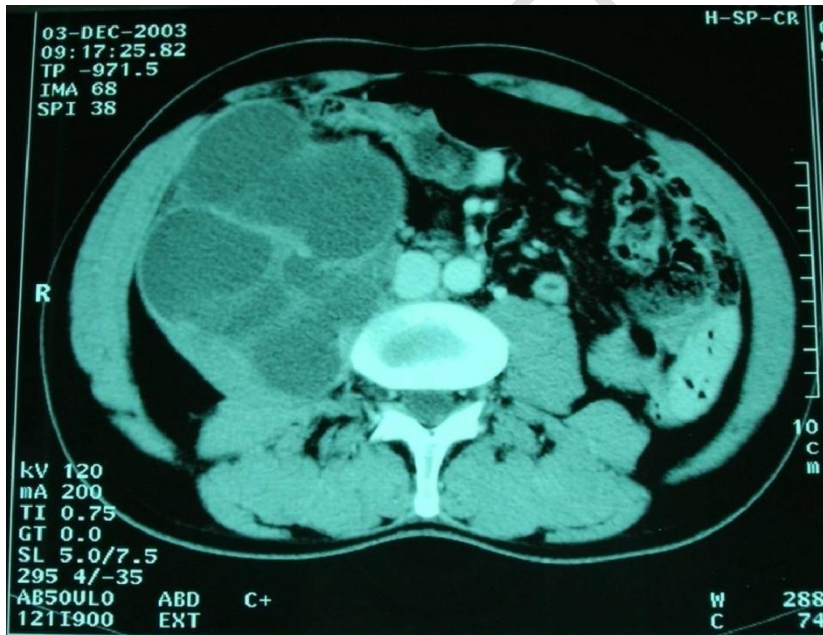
A CT scan image specifies the retroperitoneal location of the cyst in the right psoas.
